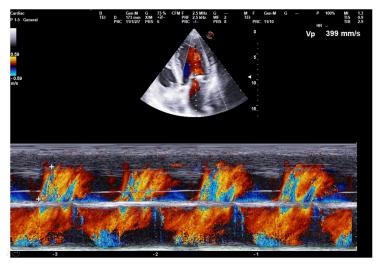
c.2. Diastolic dysfunction indicated by a decreased velocity of blood flow propagation (Vp=39 cm/s) (color M-mode, apical 4-chambers view)
